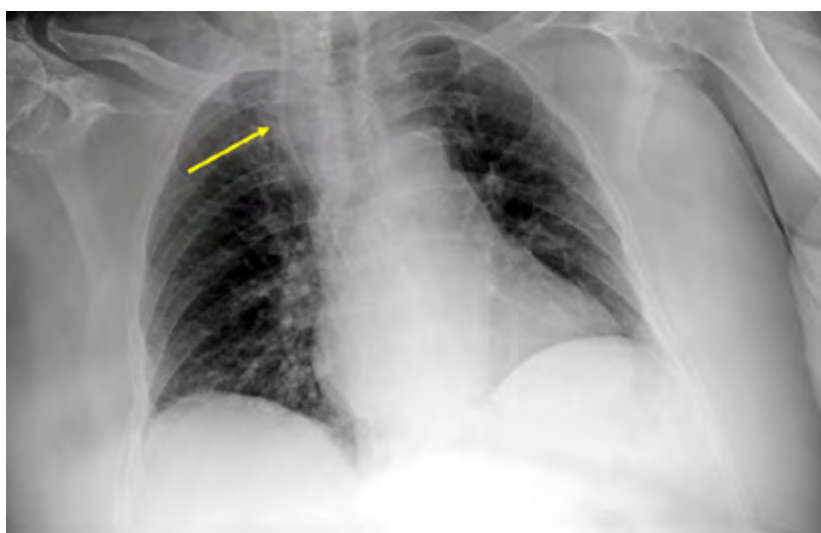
Chest AP x-ray (bedridden patient) showing the presence of CVC (arrow)
